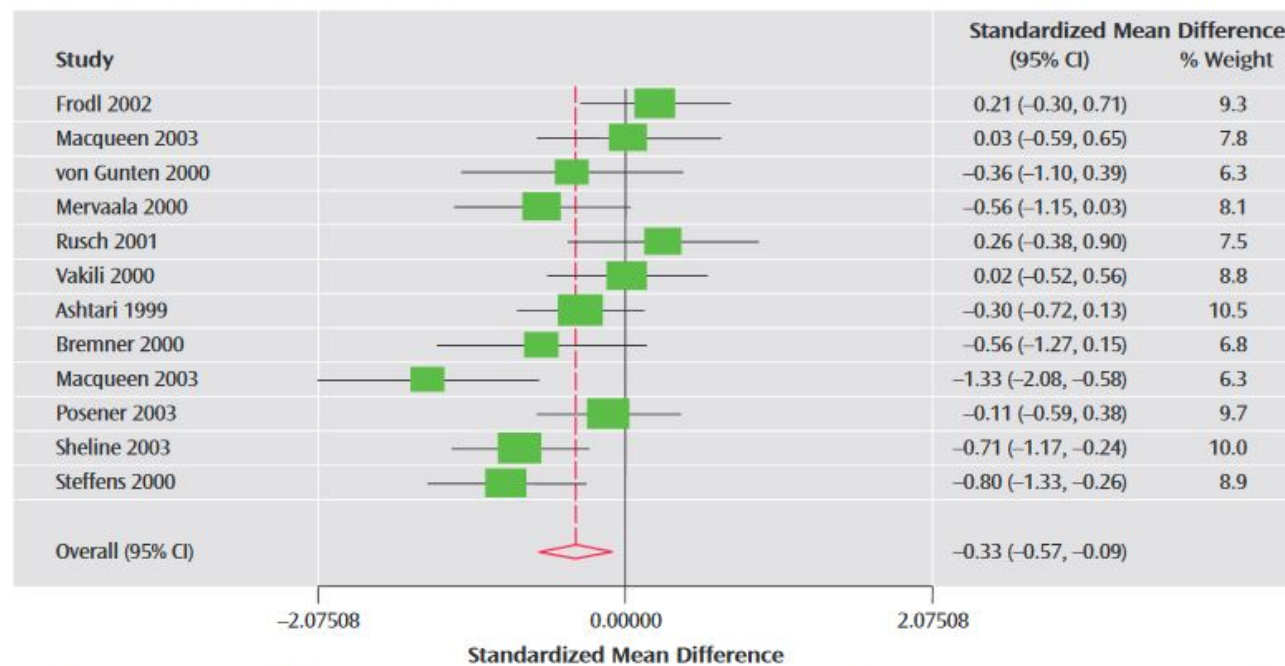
Standardized Mean Difference of Left Hippocampal Volume in Patients With Depression Relative to Comparison Subjects From a Meta-Analysis of 12 MRI Studies^a
